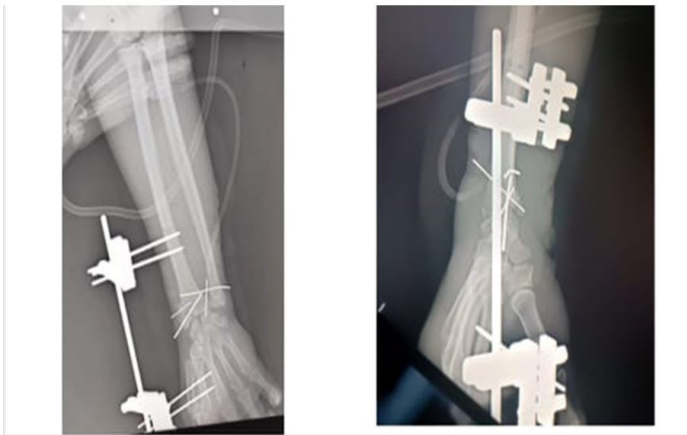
Postoperative follow-up radiography
